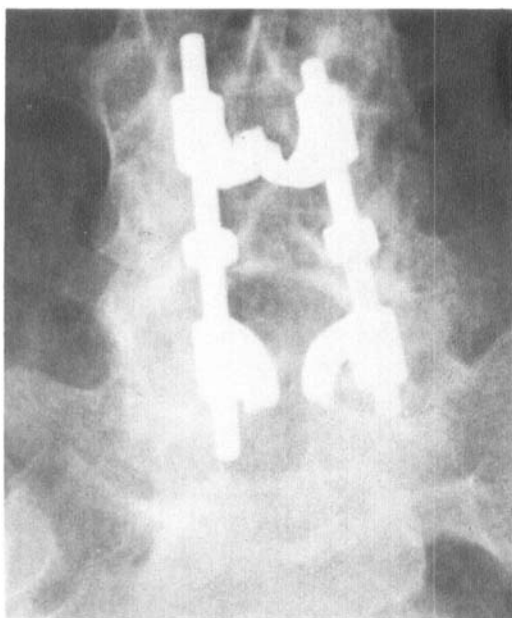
Anteroposterior and lateral radiographs showing Knodt rods *in situ*.
